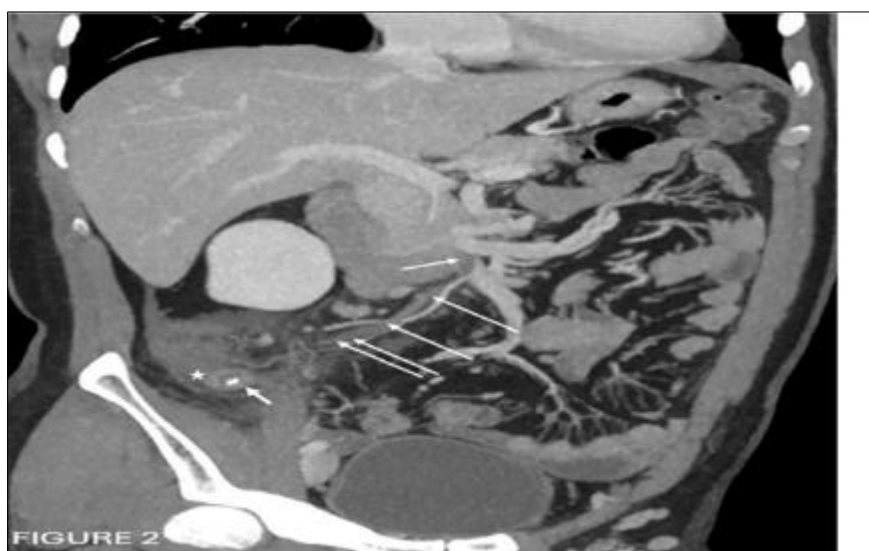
Coronal Oblique MIP image of the Contrast enhanced CT study of the abdomen demonstrating a long segment filling defect within the ileocolic vein (Long white arrows) extending to the adjoining segment of the superior mesenteric vein (short thin white arrow) suggesting thrombophlebitis. Peri appendiceal fluid (white Asterix) and thick-walled appendix containing appendicoliths (short thick arrow) are seen in keeping with acute appendicitis
